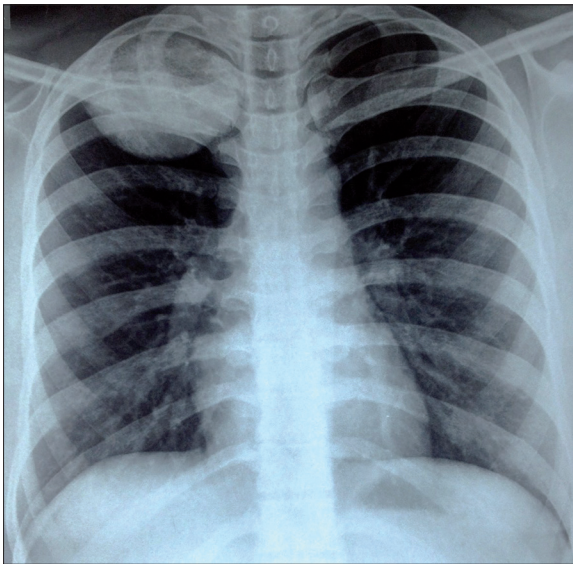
Chest X-ray shows a well-defined radio-opaque density in the right upper hemi thorax arising from the posterior part of the 3rd rib.
